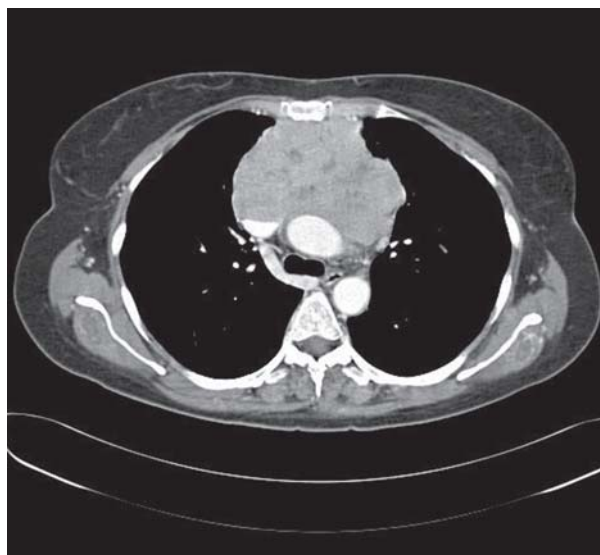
Computed tomography of the thorax showing a mass in the anterior mediastinum
